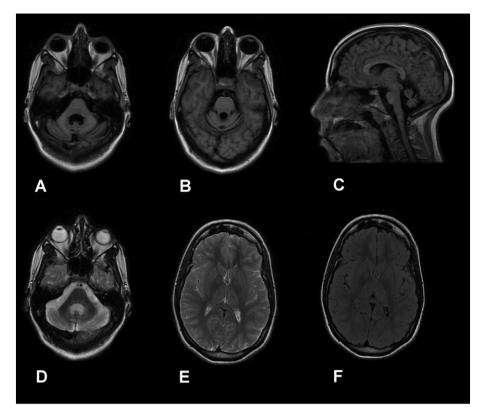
Brain MRI in patient III:3. Note the marked cerebellar and brainstem atrophy.
